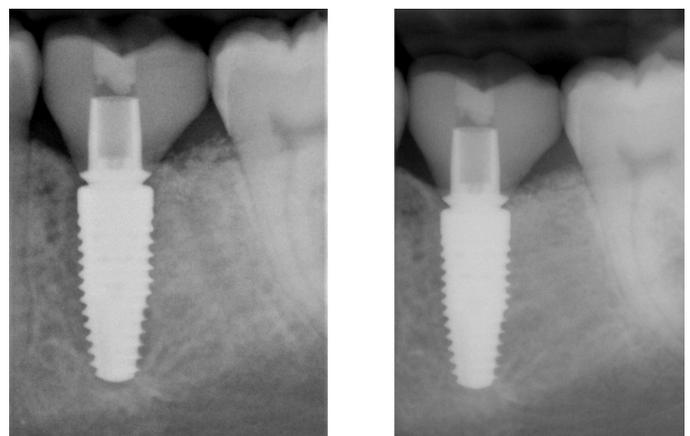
Intraoral radiographs taken at the insertion (left) and 6 months later (right).
